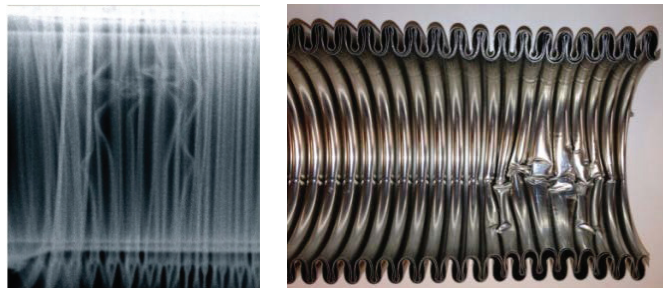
(a) X-ray of first leaky bellow; (b) photo of the first leaky extracted bellow.
